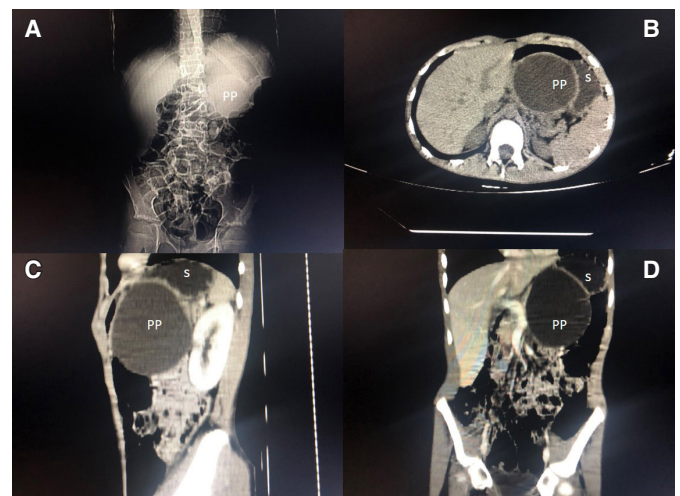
A. X-ray shows extrinsic compression of the colon and stomach by the pancreatic pseudocyst (PP) on the left flank (S). B. Transversal tomographic section where it is possible to observe a large cystic formation with stomach compression. C. Sagittal section showing the location of PP in relation to other abdominal organs. D. Coronal section showing the location of PP in relation to other cavitory organs.
